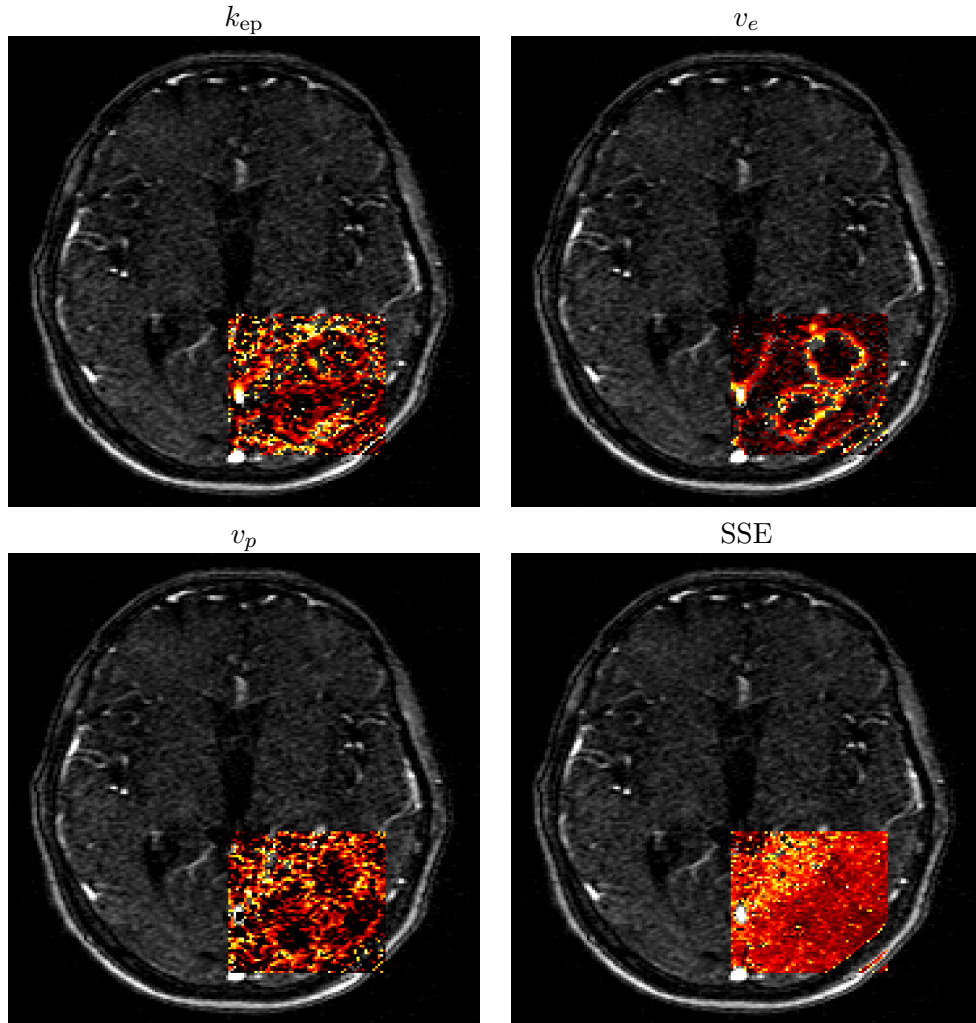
Statistical images of the RIDER Neuro MRI data using non-linear regression for slice $z = 7$. The parameter k_{ep} is the rate constant between EES and blood plasma (units are $[0, 1.25] \text{ min}^{-1}$), v_p is the vascular space fraction of plasma (units are $[0, 30] \%$) and v_e is the EES space fraction (units $[0, 30] \%$). The sums-of-squared error (SSE) measures the quality of fit over the tumor region-of-interest (units are $[0, 0.05]$).
